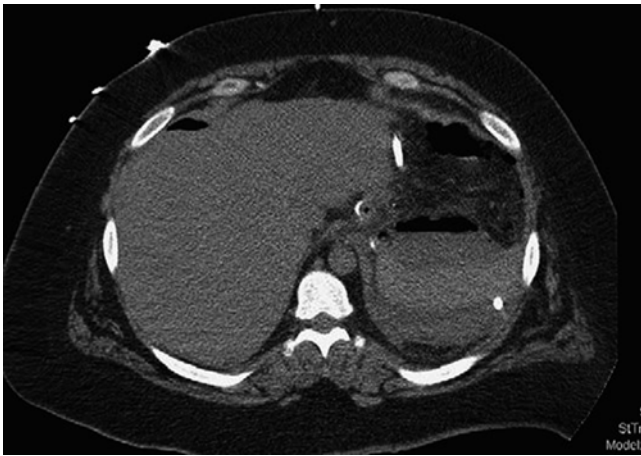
CT scan showing a left upper quadrant abscess after post-LSG GL.
